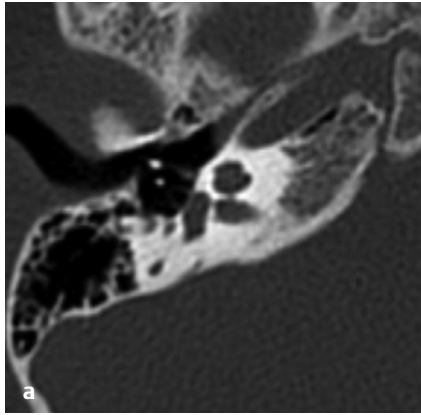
(a) HRCT temporal bone window and (b) MRI CISS sequence, axial sections shows narrow cochlear aperture with hypoplastic cochlear nerve.
